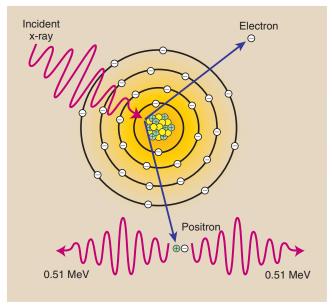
Pair production occurs with x-rays that have energies greater than 1.02 MeV. The x-ray interacts with the nuclear field, and two electrons that have opposite electrostatic charges are created.
